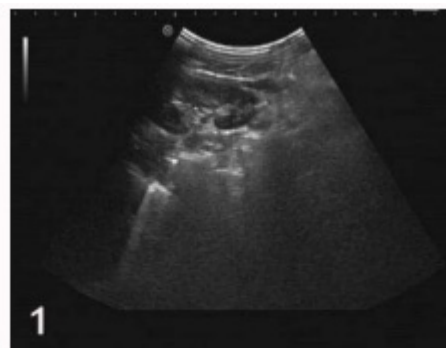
Preoperative ultrasound results.
